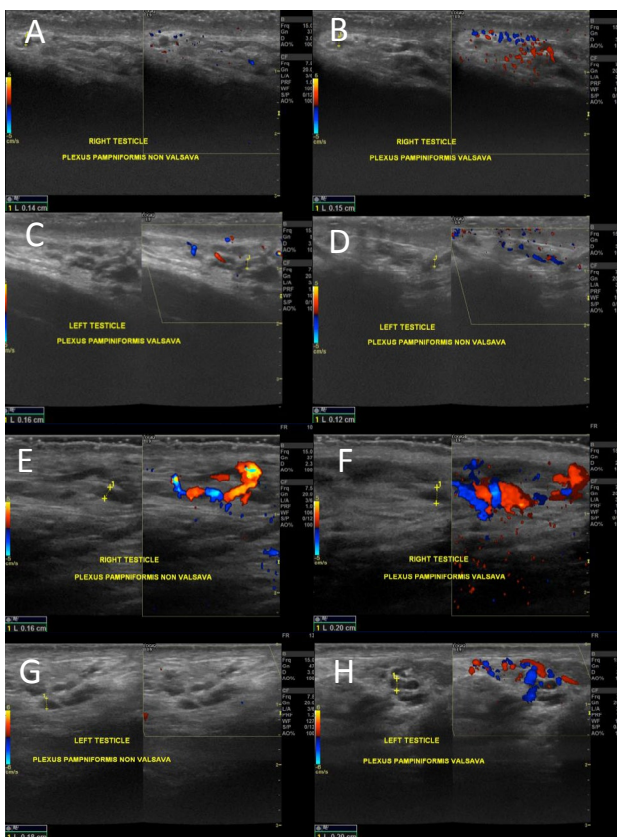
Doppler ultrasound of grade 0 varicocele. A is the right testicle and C is the left testicle. Both showing plexus pampiniform diameter below 2 mm in relaxed supine position. B and D showing both left and right pampiniform plexus increased in diameter below 2 mm. Doppler ultrasound of grade I varicocele. E is the right testicle and G is the left testicle. Both showing plexus pampiniform diameter below 2 mm in relaxed supine position. Both right (F) and left (H) pampiniform plexus diameter increased between 2-3 mm during Valsava maneuver
